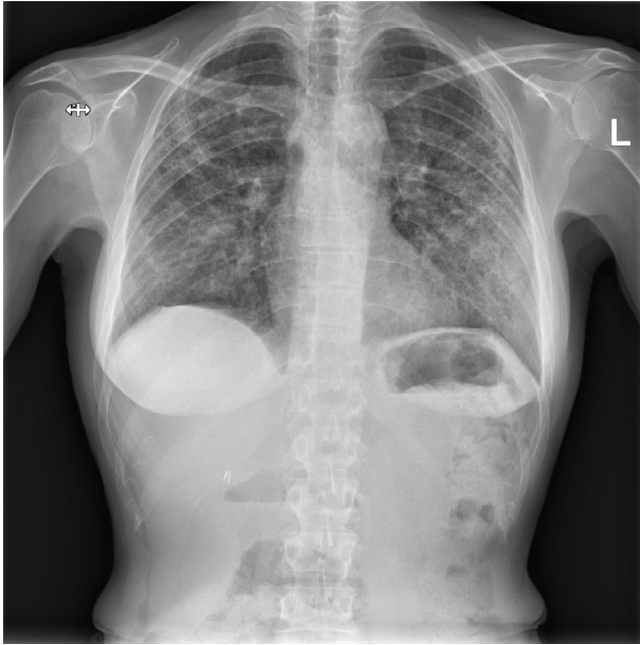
(Patient 1): Follow-up chest x-ray demonstrating complete resolution of pneumomediastinum and subcutaneous emphysema.
